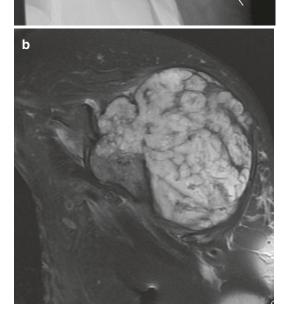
Chondrosarcoma: 86-year-old female presenting with enlarging left shoulder mass and decreased range of motion. (a) AP radiograph demonstrates a large soft tissue mass originating from the left humeral greater tuberosity with significant bone destruction, poorly defined bone margins, and a large soft tissue mass which defined margins and heterogenous internal calcification (*arrows*). (b) Coronal T2 MR image same patient demonstrating heterogenous high signal intensity of the chondroid matrix
